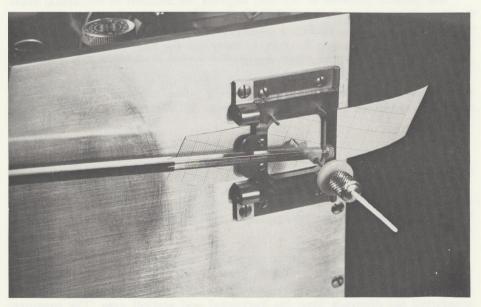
6. A strip of graph paper is inserted in the cassette in front of the x-ray film. Movements of the stylus can be analyzed more easily against this background. After a registration the paper is advanced until the perforation is beyond the window. During the whole operation the underlying extension of the articulator axis shaft is hidden from view.
